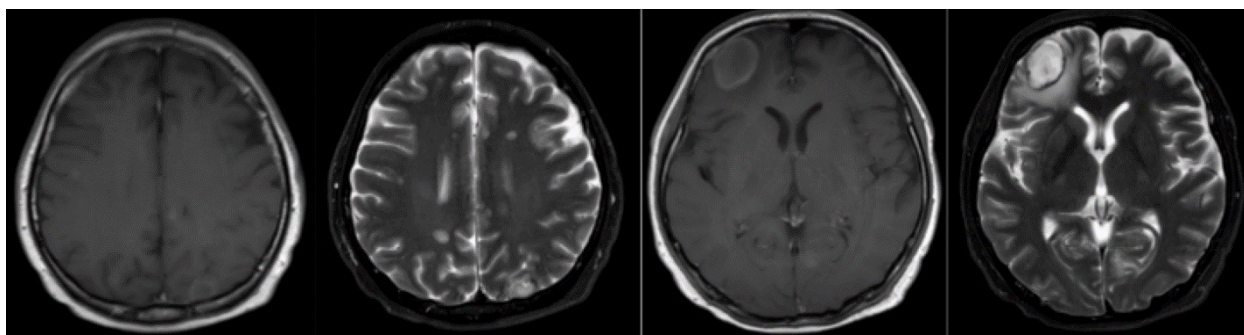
MRI brain on the day of stopping Crizotinib.
